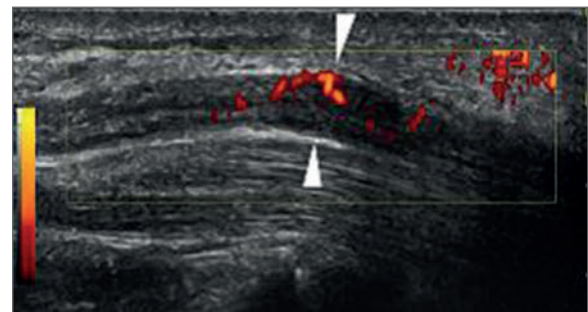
Longitudinal image of the median nerve at the level of the carpal tunnel. There appears to be a mild swelling of the nerve as it enters the tunnel (white arrowheads). Doppler imaging demonstrates a mild intraneural vascularity suggestive of carpal tunnel syndrome.
